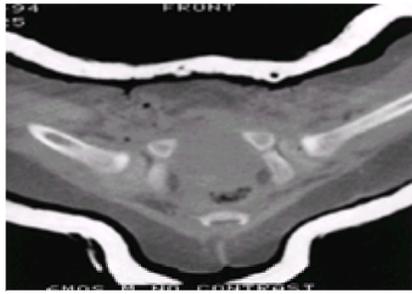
This computed tomography scan documents a successful closed reduction of a right hip dislocation. The plaster cast is molded dorsal to the greater trochanters to help prevent redislocation.
